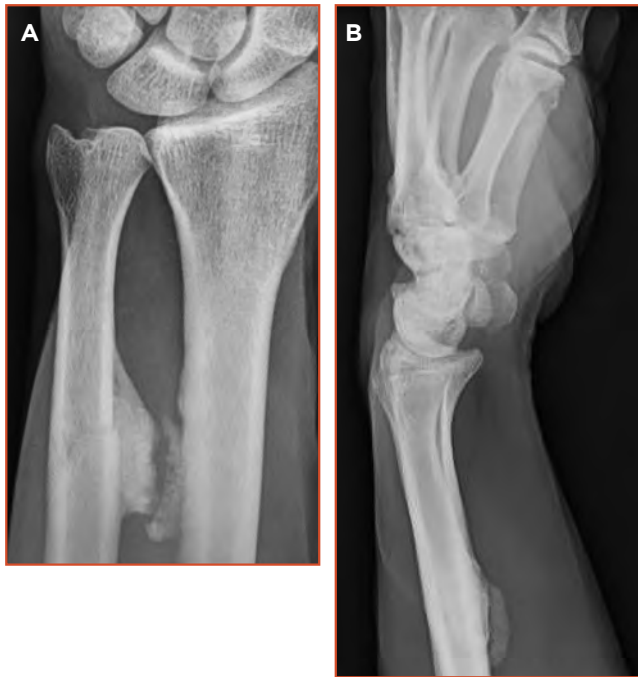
Radiographs of the left forearm, showing an isolated non-displaced fracture of the distal third of the ulna with extensive callus formation invading the interosseous space. A) Anteroposterior view. B) Lateral view.
